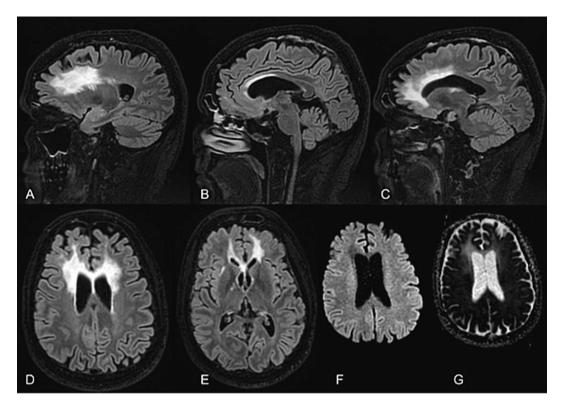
A follow-up brain MRI was performed three years later, using sequences and positions similar to those in Fig. 1. Compared to the previous study, there is an increase in T2-FLAIR white matter hyperintensities in the bilateral frontal periventricular areas, now extending to the internal capsule. This is accompanied by moderate enlargement of the lateral ventricles, suggesting atrophy. Additionally, there is a greater posterior extension of T2-FLAIR hyperintensity within the body of the corpus callosum, while the anterior portion appears slightly thinner, consistent with atrophic progression. No restricted diffusion is observed in the abnormal white matter.
